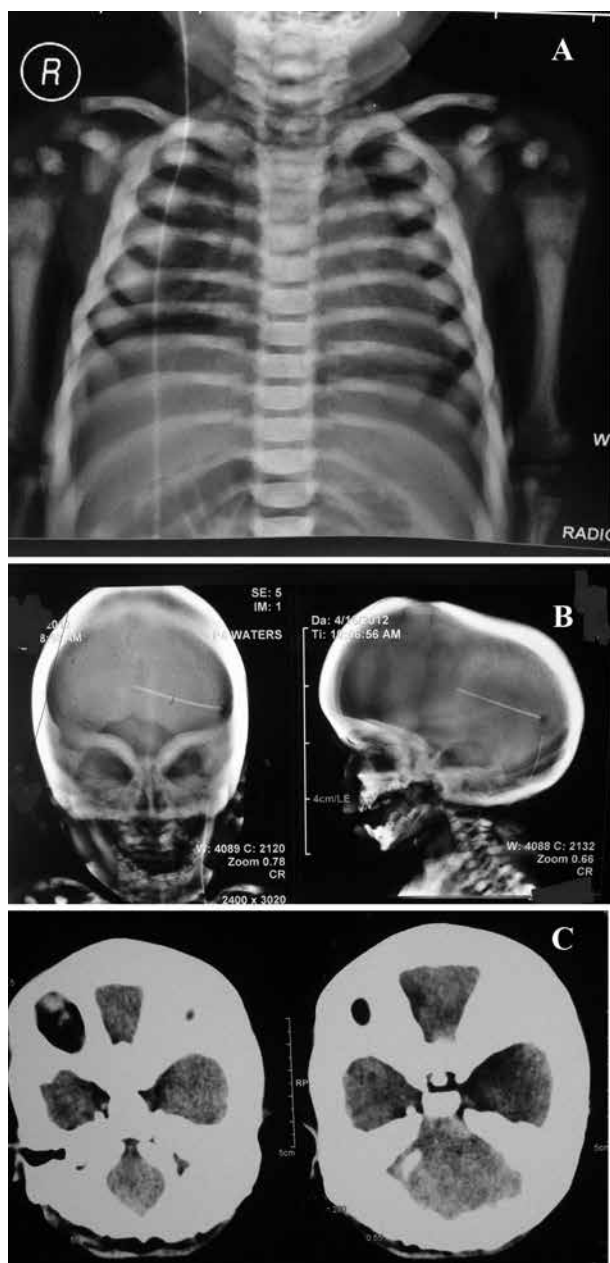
A, Chest X-ray of patient of osteopetrosis presented with hydrocephalus which managed with ventriculoperitoneal shunt. Note the increased density of bone in the ribs, limbs, and vertebral column; B: Skull X-ray of a patient presented with hydrocephalus needed shunt procedure shows severely thick and dens cranium, especially in the skull base region, and underpneumatized paranasal sinuses and mastoid air cells, C: Axial slices of brain CT scan confirm very dens skull base and narrow foramen magnum.
